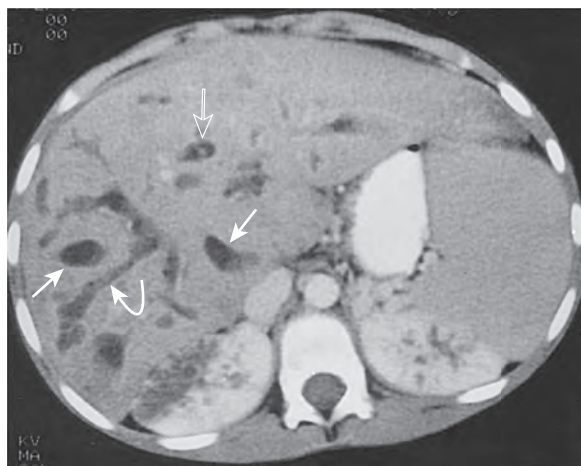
Caroli's disease: CT findings. The dilated segments of the intrahepatic biliary tract may be visualized as "cysts" (straight arrows), which are occasionally attached to more proximal ectatic segments of the biliary radicles (curved arrow). The defining CT feature of Caroli's disease is the central dot sign (open arrow). There is ectasia of the distal nephrons in the kidneys. (From Taylor AJ, Bohorfoush AG: *Interpretation of ERCP with Associated Digital Imaging*. Philadelphia, Lippincott-Raven, 1997, p 52, with permission.)
